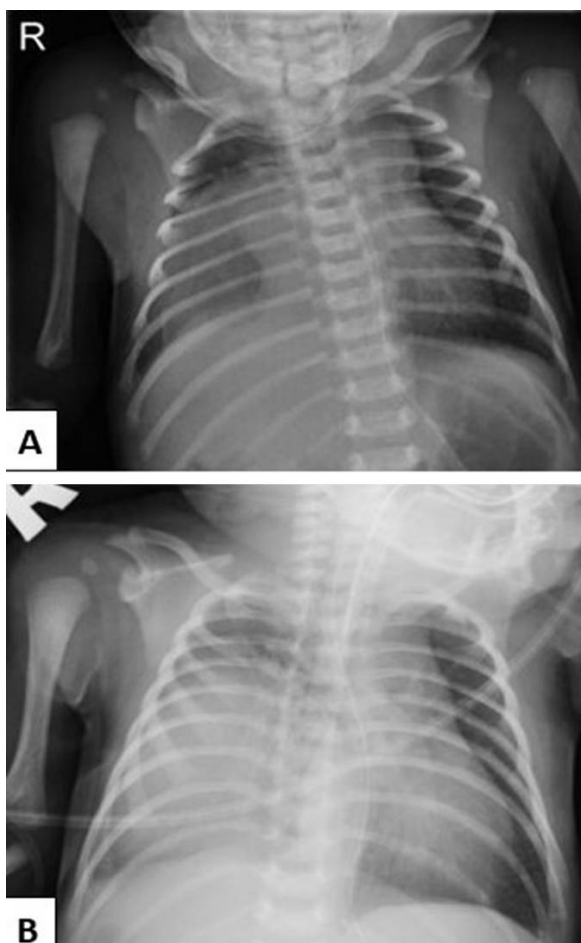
(A) Chest radiograph (PA) acquired at day 1 of life shows opacity at the right mid and lower zones. (B) The subsequent radiograph at day 10 of life shows no significant changes despite completion of antibiotic. (Click on image to enlarge)
